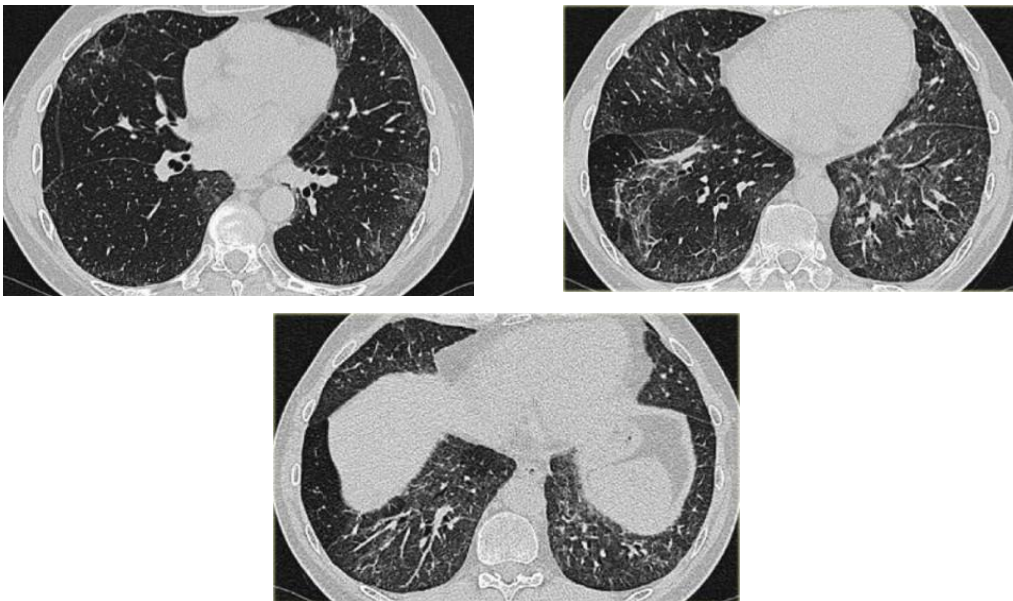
HRCT images of a patient with a NSIP
